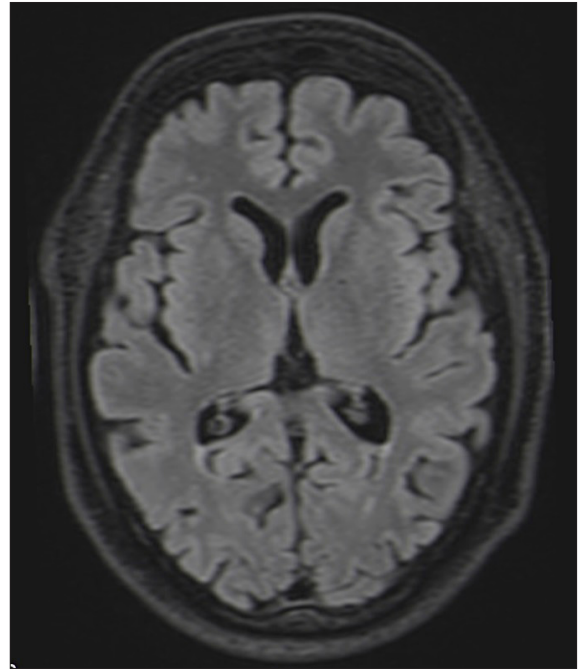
Reevaluating MRI showing reduction in signal intensity and the extent of edematous changes.
